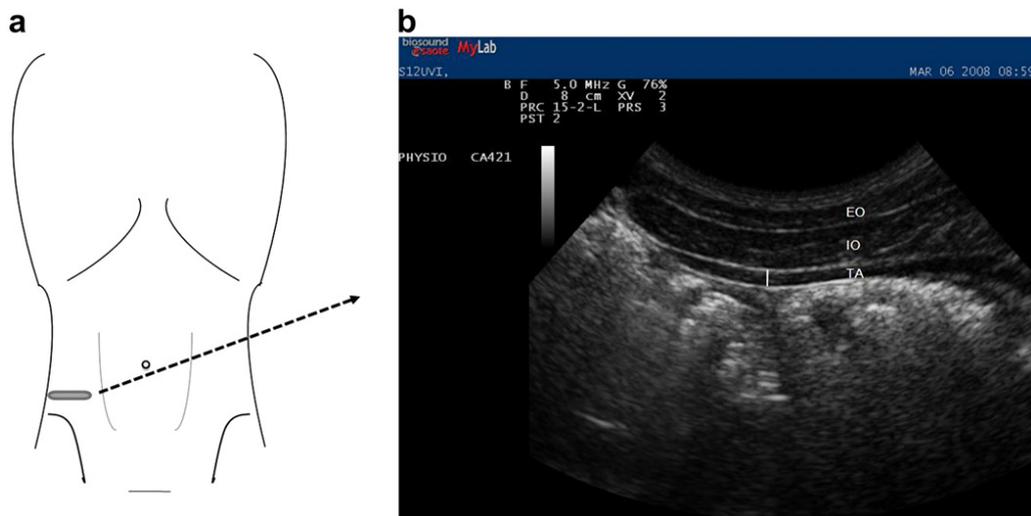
(a) Lateral abdominal wall (LAW) transducer imaging site. (b) Transverse ultrasound image of the right lateral abdominal wall showing the thickness of the transversus abdominis muscle defined as the perpendicular distance between the muscles' superficial and deep fascial boundaries. EO = external oblique; IO = internal oblique; TA = transversus abdominis.
